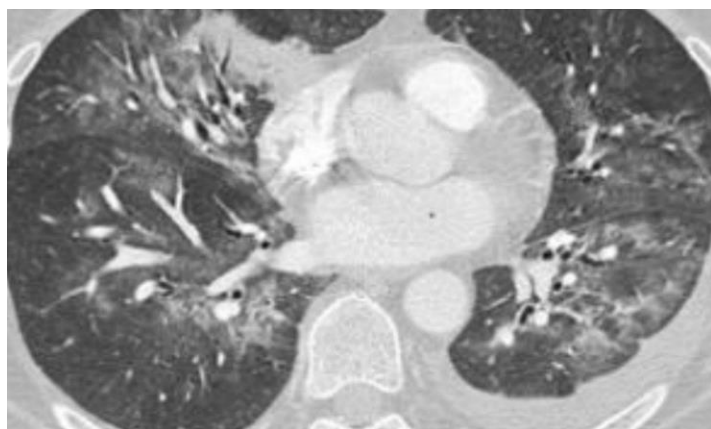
Serial CT scans showing multifocal consolidation.
